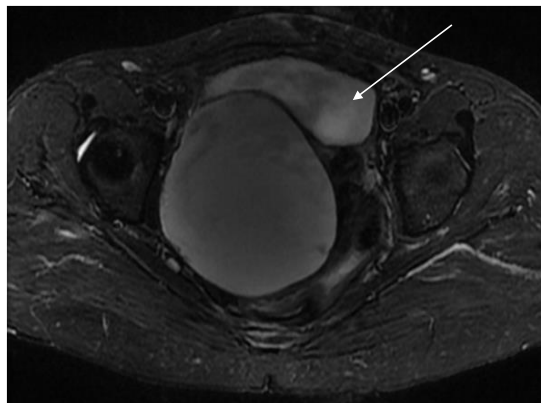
Magnetic Resonance Imaging (MRI) of ileal pouch demonstrating mucinous tumour (see arrow).
